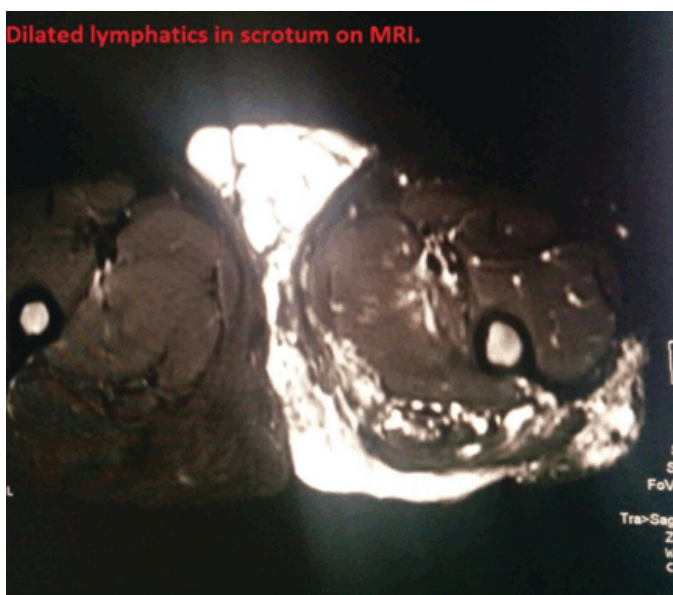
MRI of pelvis showing dilated lymphatics.
